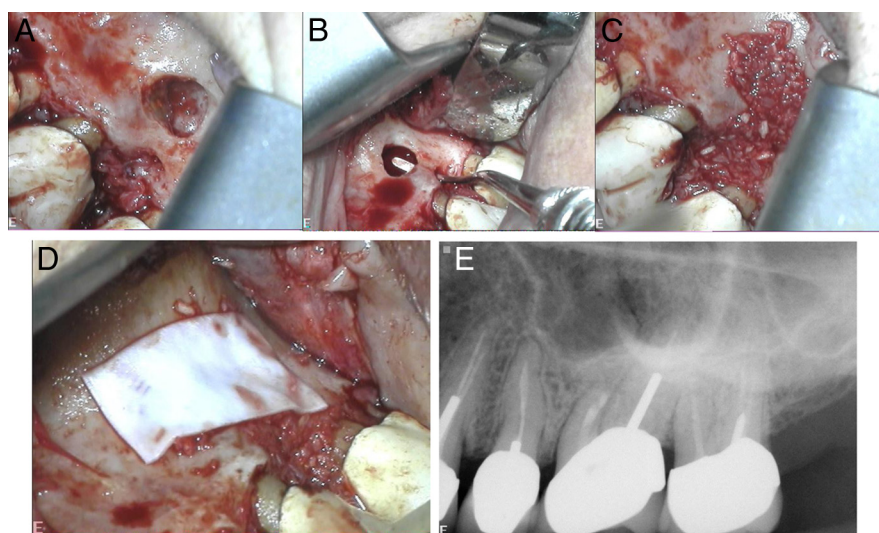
Case 3 continued: (A) A clinical picture after flap reflection showing both crestal and periapical lesions. (B) Communication between both defects. (C) Both defects grafted with an EnCore combination allograft (Osteogenics Biomedical, Lubbock, TX). (D) CopiOs pericardium membrane (Zimmer, Warsaw, IN). (E) An immediate postoperative radiograph.
